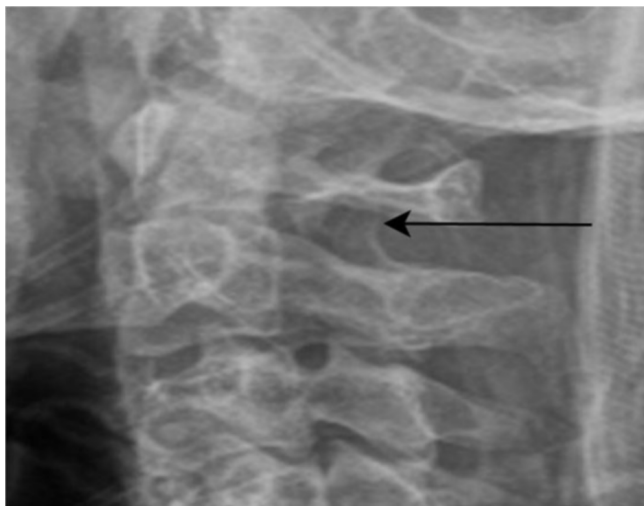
Cross table lateral radiograph of the cervical spine demonstrates osteochondroma (arrow) arising from the left C2 lamina and projecting into the spinal canal.
